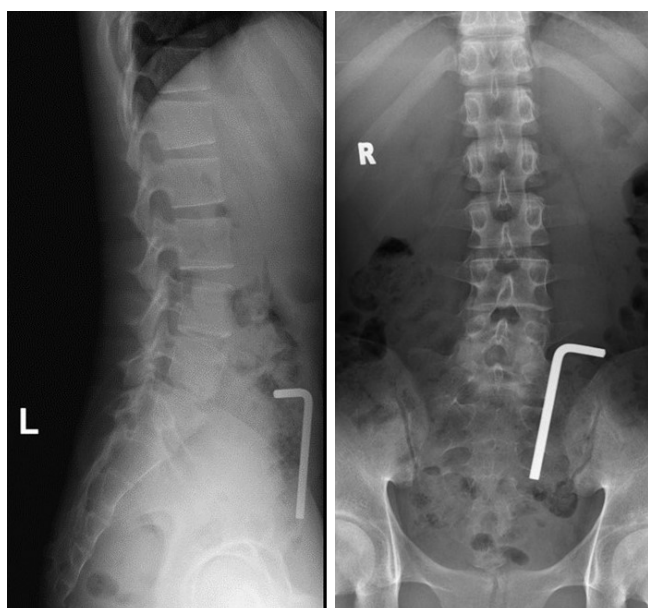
Initial anteroposterior and lateral lumbosacral radiographs showing a radio-opaque L-shaped foreign body on the left side of the abdomen.
